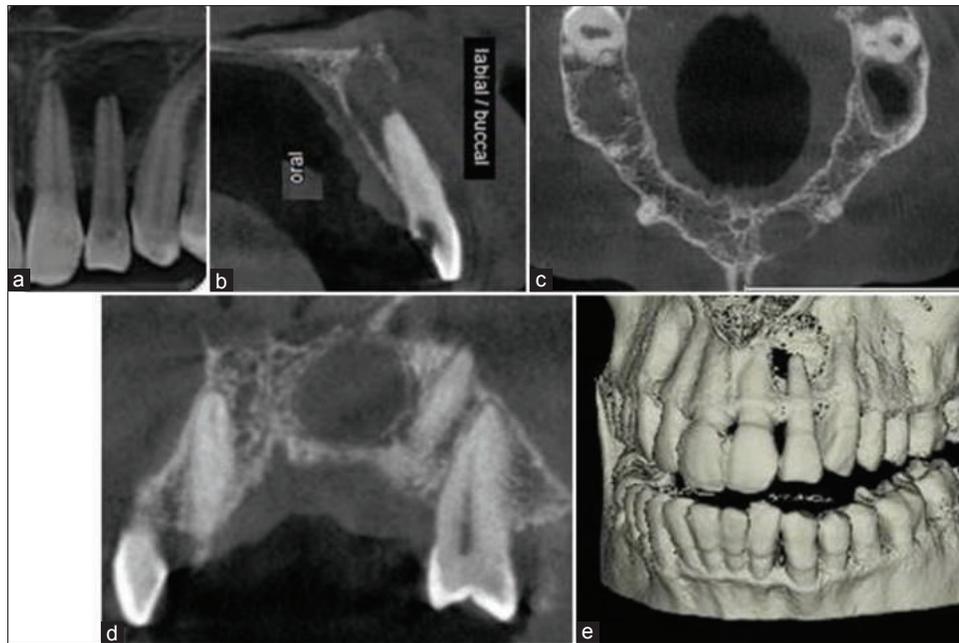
Periapical lesion. (a) Conventional intraoral periapical radiograph of tooth 22. (b and c) Cross-section and axial cone-beam computed tomography image of the same tooth revealing the loss of palatal cortex. (c and d) Tangential and three-dimensional reconstruction image showing the dramatic extent of lesion. (e) Three dimensional reconstruction (surface volume) depicting the loss of bone in the labial cortex and the proximity of the lesion to the floor of the nasal fossa
